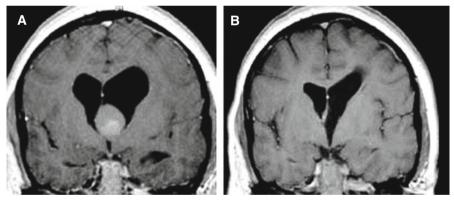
Pre-operative (A) and post-operative (B) axial MRI of a case of a colloid cyst of the III ventricle
